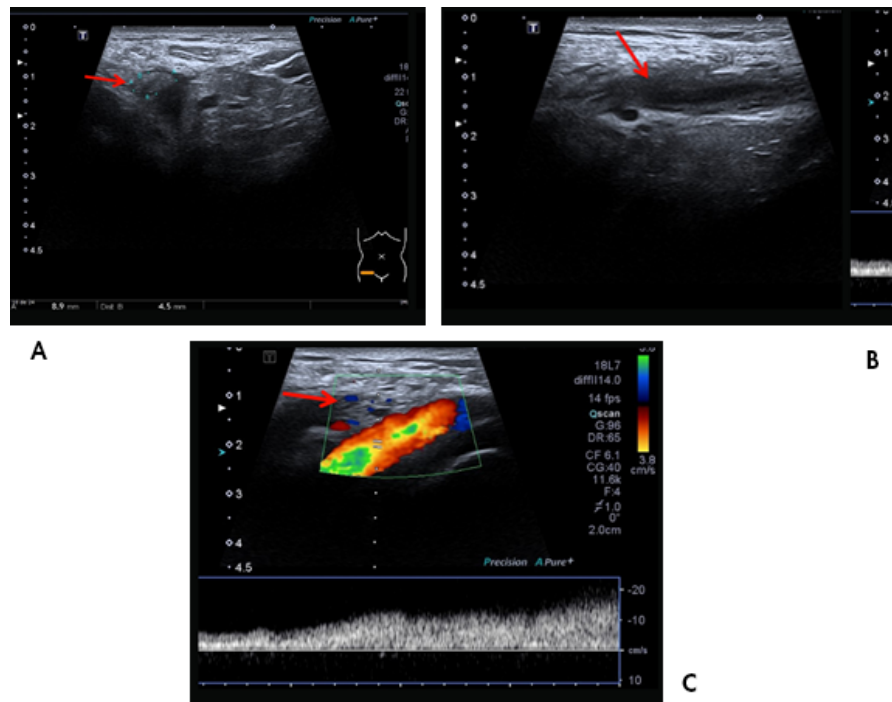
Ultrasound study. A) right spermatic vein thrombus (arrow); B) longitudinal view of right spermatic vein with intraluminal thrombus (arrow); C) Doppler analysis showing disturbance of venous flow at the thrombus site in the spermatic vein (arrow).
